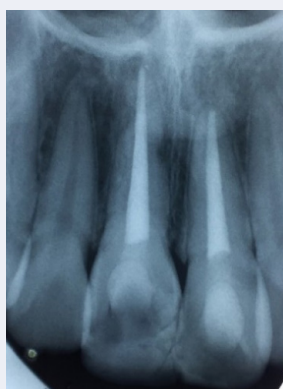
Three years nine months after the trauma. Periapical radiograph Tooth 11 external root resorption (1x3 mm.) at the mesial area around middle 1/3 of the root and infra-occlusal position. Tooth 21 no periapical lesion or external resorption.
